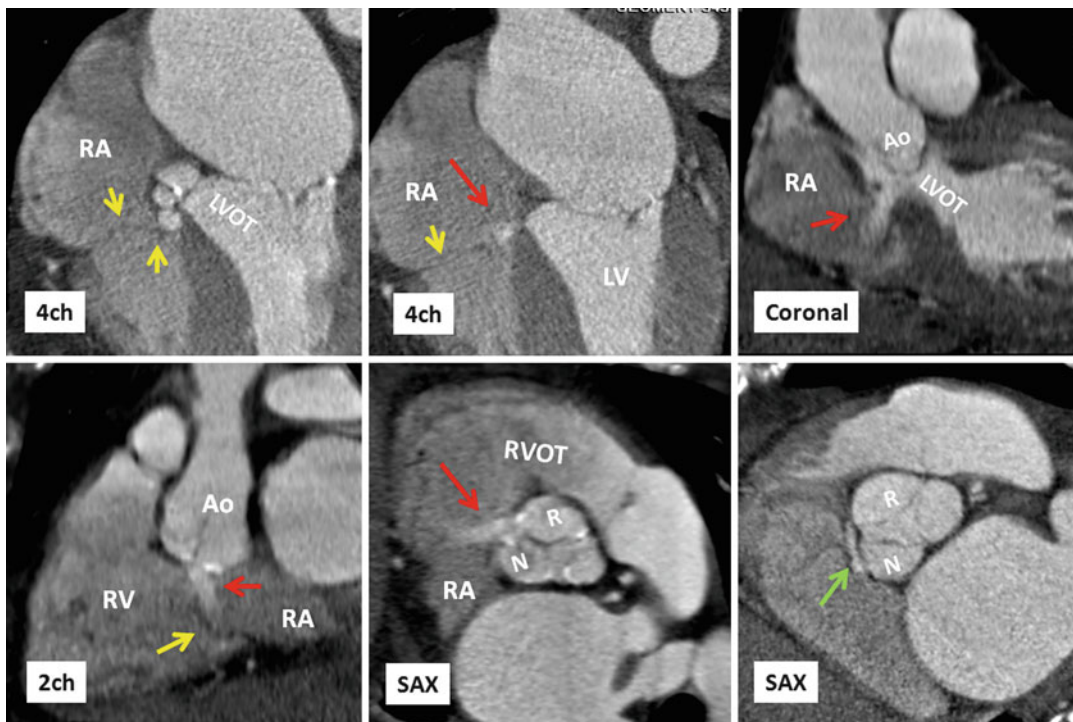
Atrioventricular membranous defect (Gerbode) in a 73-year-old male with aortic valve disease. Calcified valve with vegetation and mild regurgitation was shown on echocardiography. Different projections of CT angiography show small membranous defect with shunt (red arrows) from the left ventricle (LV) into the right atrium (RA). The shunt was more obvious during diastole arising
